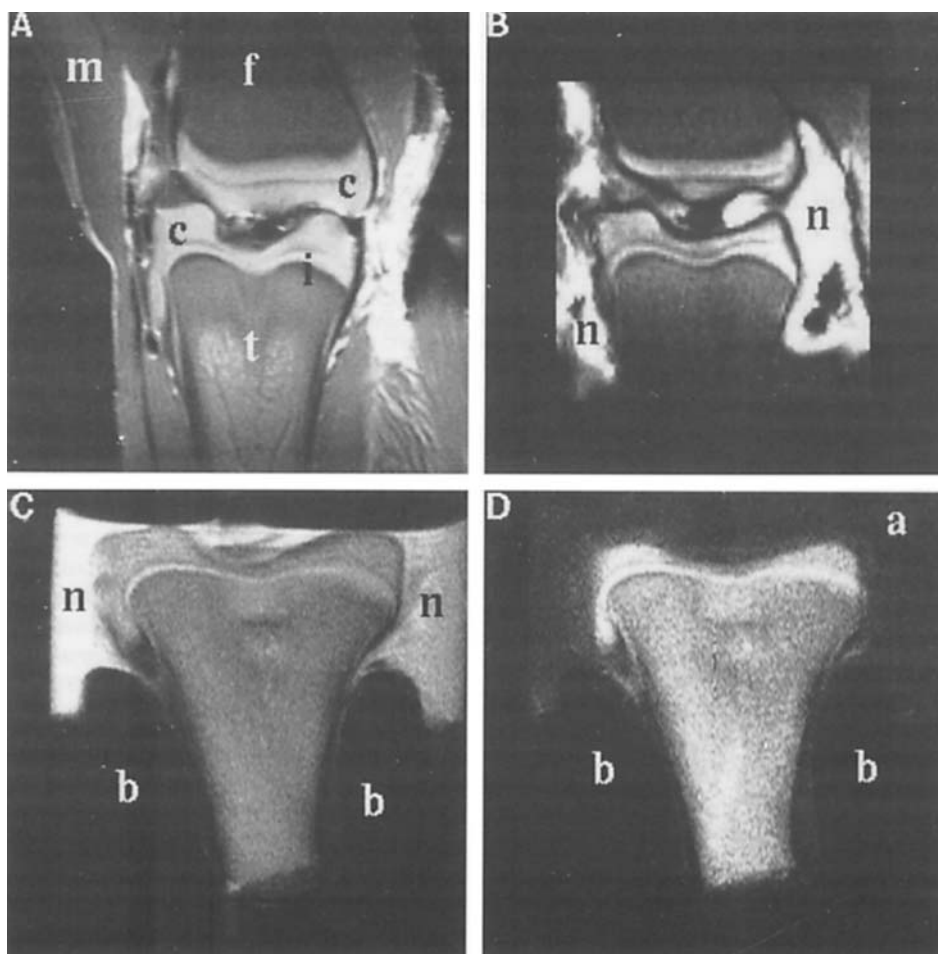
MR images of the same intact hen knee joint. A, the intact joint. B, following the partial perfusion of nitroxide through the cartilage. For a disarticulated joint, C, after perfusion of through the cartilage into the bone marrow. D, after partial perfusion of ascorbic acid.
